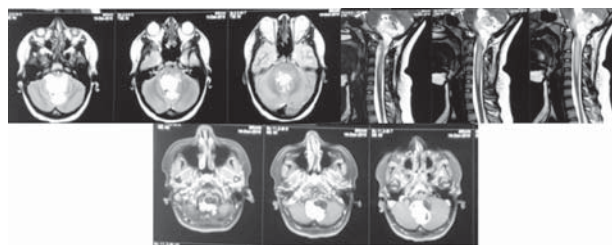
Contrast-Enhanced MRI Brain revealed Intensely enhancing lesion noted at midline posterior fossa arising from cerebellar vermis. There is intensely enhancing solid component appearing hypo to isointense on T1 and hyperintense on T2 and few cystic areas within the lesion.
